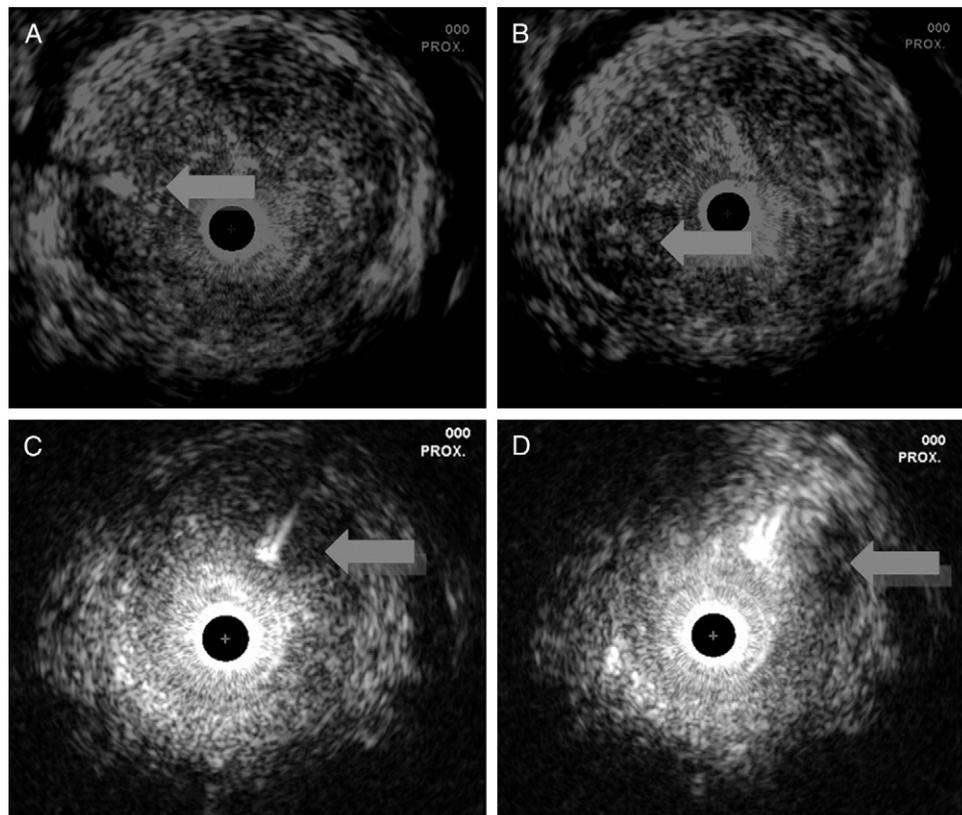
Ultrasound guided injection of autologous myoblasts and fibroblasts in incontinent patient. *A*, tip of needle (arrow) is located at inner aspect of rhabdosphincter (9 o'clock position). *B*, subsequently small depot of myoblasts ($50 \mu\text{l}$) is injected (arrow). *C*, after injection of myoblasts, fibroblasts are injected into urethral submucosa (1 o'clock position). *D*, small depots of fibroblasts can be visualized.
